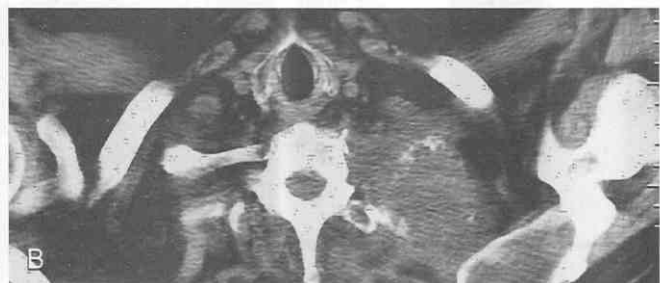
Non-small-cell lung cancer in a 54-year-old man with Pancoast's tumor and with a 2-month history of neck pain. *A*, Posteroanterior chest radiograph shows a left apical mass with destruction of the first rib (arrowheads). *B*, CT confirms the left superior sulcus tumor and destruction of the left first rib.
